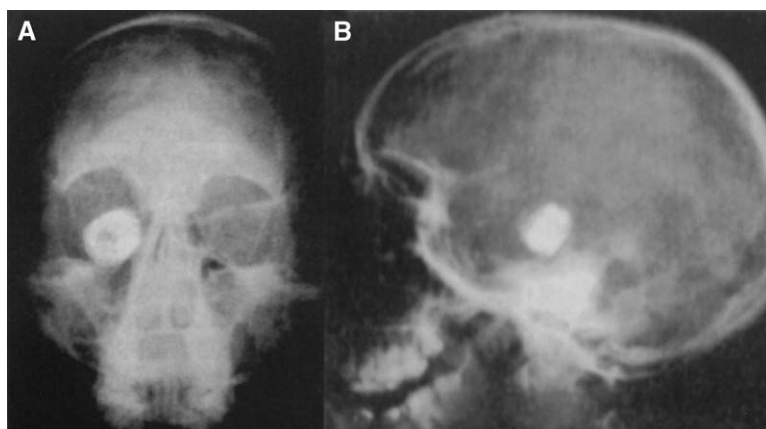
Anteroposterior (A) and lateral (B) follow-up cranial radiographs of the patient whose aneurysm was successfully treated with a silver wire inserted through the orbit. (From Werner SC, Blakemore AH, King BG. Aneurysm of the internal carotid artery within the skull: wiring and electrothermic coagulation. JAMA 1941;116:578–82; with permission.)
